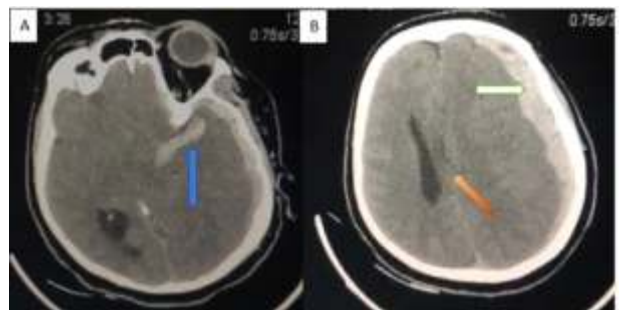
Initial CT showing intraparenchymal haemorrhage (blue arrow), subdural hematoma with no features of subarachnoid haemorrhage (white arrow). There was almost complete left lateral ventricle compression with >10mm midline shift.
